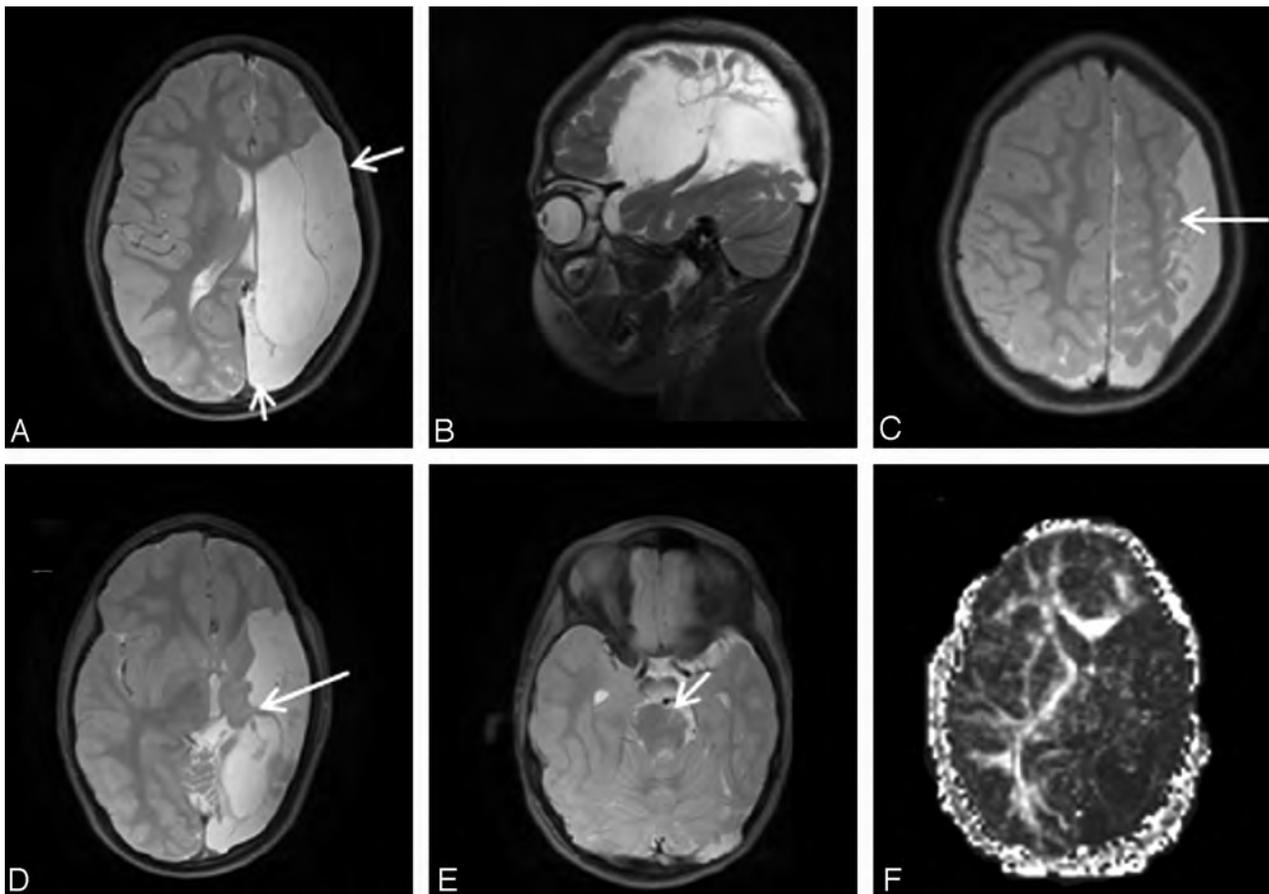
Images from an 8-year-old boy with right hemiplegia and MACS score of 3, with a background of left MCA infarct, born at term. *A*, Axial T2-weighted image, and *B*, sagittal T2-weighted image, both demonstrate involvement of all 4 lobes (4 points). Extensive cystic and gliotic changes are present (2 points). In this case there is obvious severe white matter volume loss, which makes actual measurement redundant (3 points). There is extensive loss of cortical gray matter with thinning and gliosis in adjacent gray matter (1 point) as shown in *C*. *D*, Extensive involvement of deep gray matter structures (4 points), as well as major white matter tracts including external capsule and anterior and posterior limbs of the internal capsule (3 points). *E*, Asymmetry of the pyramids (1 point). When DTI is available, the anisotropy map can help in delineating the white matter tract involvement as seen in *F*. The total score was 18.
